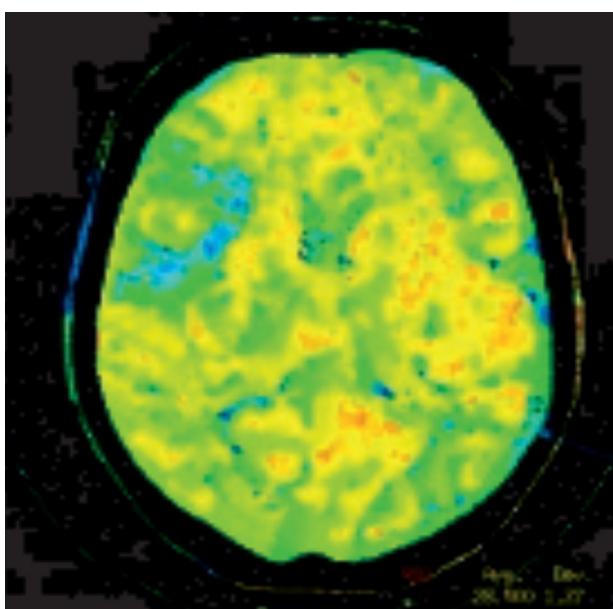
CT perfusion after thrombolitic therapy with rescued penumbra
